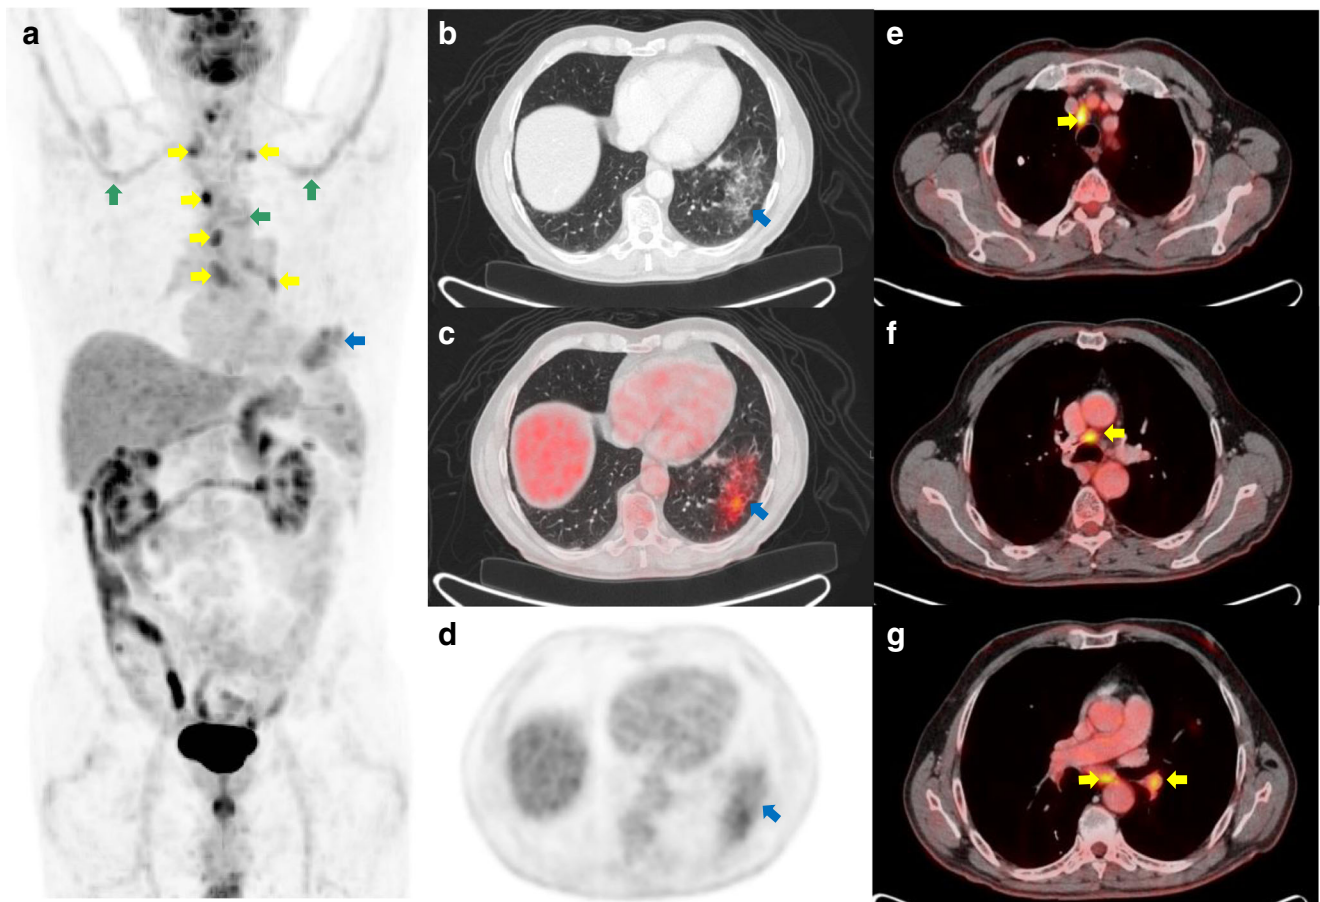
A 79-year-old male with malignant ampulloma resected in 2017. PET-CT was performed due to suspicion of recurrence. (a) Maximum intense projection (MIP) demonstrating increased metabolic uptake in left lung base (blue arrow) and supraclavicular and mediastinal lymph nodes (yellow arrow). Axial views of (b) CT, (c) fusion, and (d) PET images
